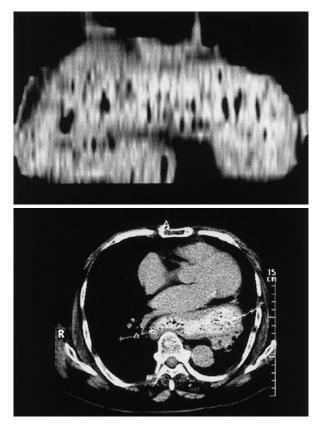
Three-dimensional curved reformation computed tomography scan
